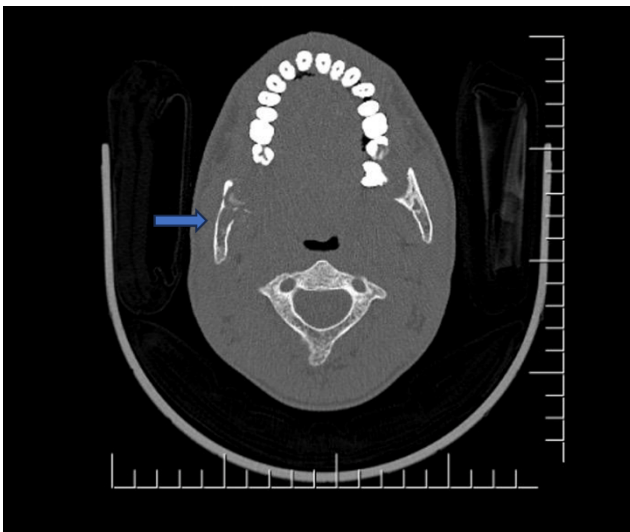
Axial CT image (bone window) demonstrating extensive lytic involvement of the bilateral mandibular rami with areas of focal cortical breach (arrow).
